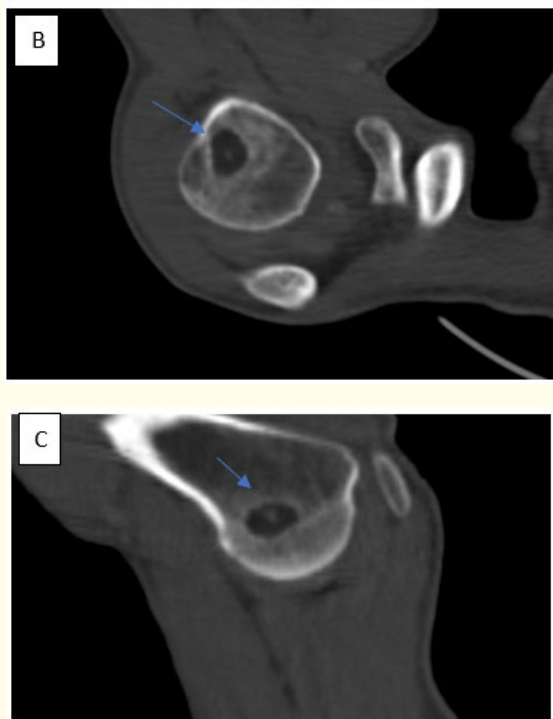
Coronal (A), axial (B) and sagittal (C) CT images in the bone window, showing in the right humeral head a well-defined lytic lesion with a fatty density measuring -55 HU.
